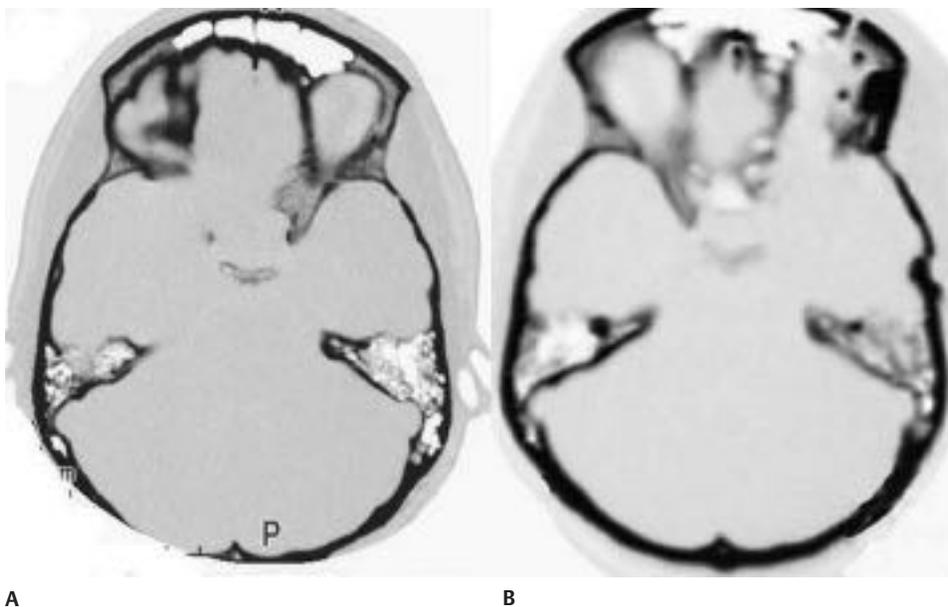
Computed tomographic (CT) scan demonstrating hyperostosis indicative of bony invasion that requires surgical resection. (A) Preoperative CT scan, bone window. (B) Postoperative CT scan demonstrating removal of the hyperostotic bone.
